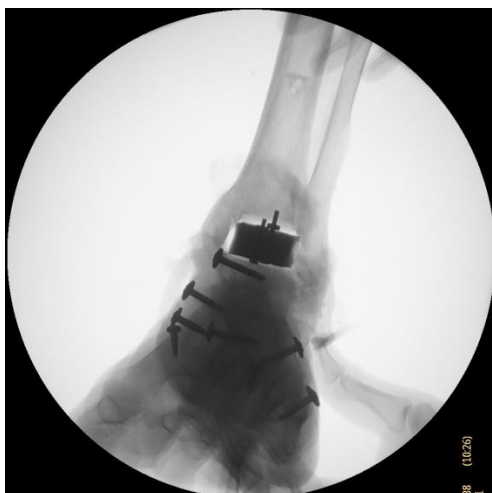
A mortise radiograph to determine ML neutral position (this image seems like good alignment, but a better radiograph directly perpendicular to the side of the fixture would be preferable).
